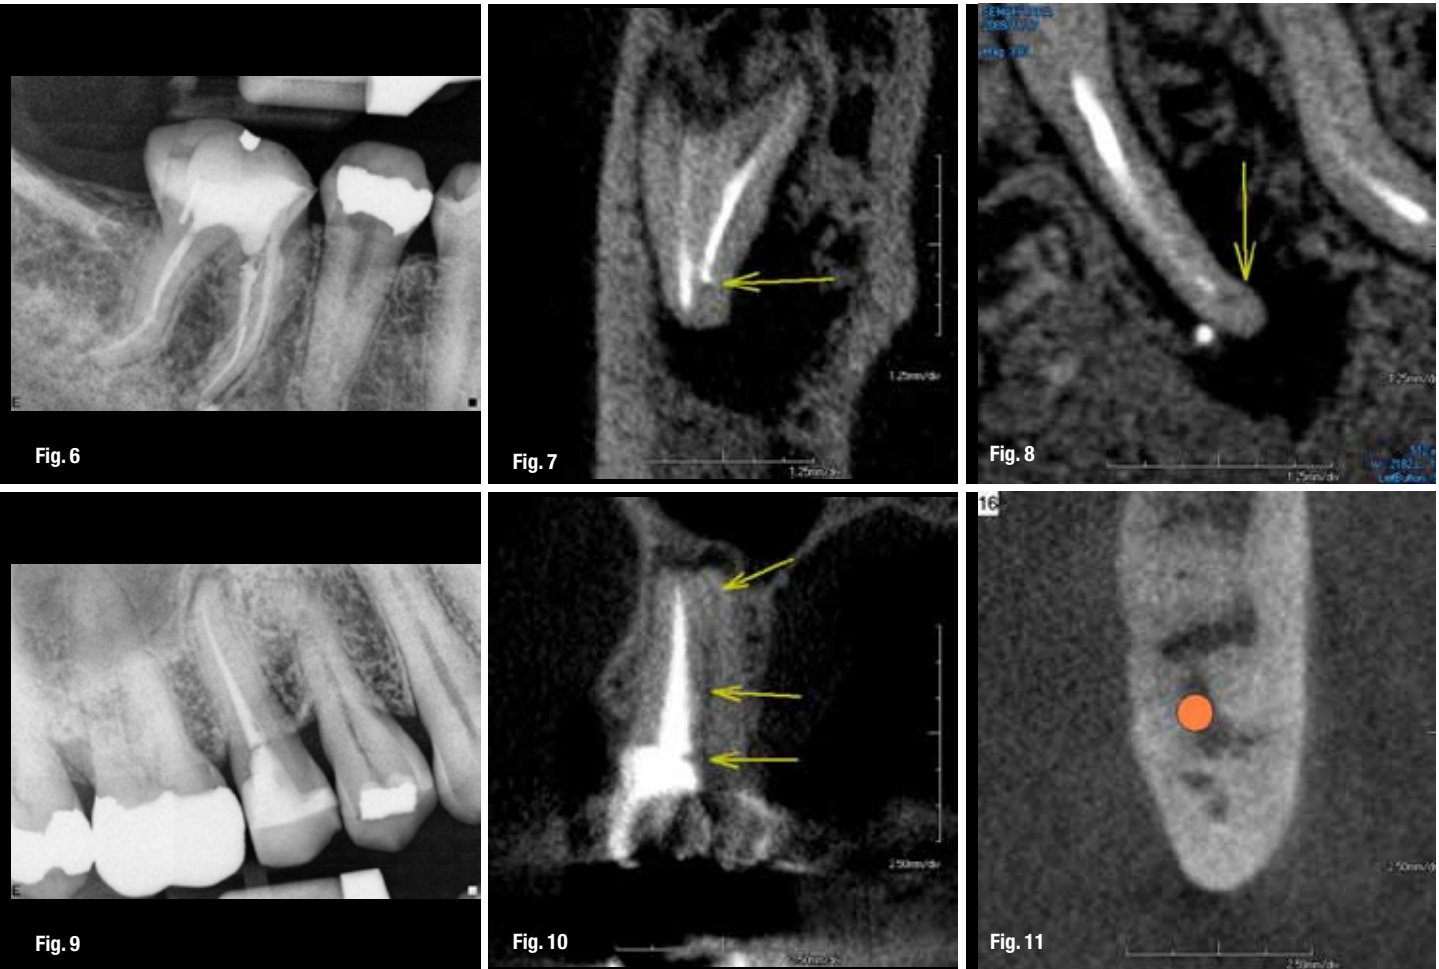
Periapical showing minimal pathology with no radiolucency.
